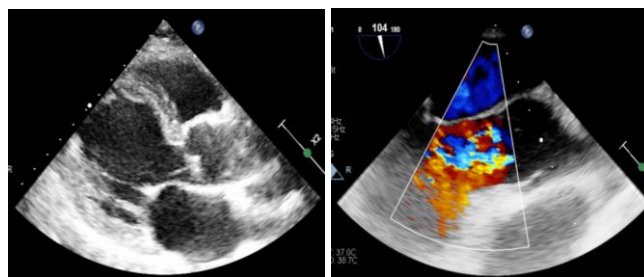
Transthoracic echocardiogram showing mobile filiform vegetation (1.9 cm) attached to the aortic valve with a left coronary cusp perforation
